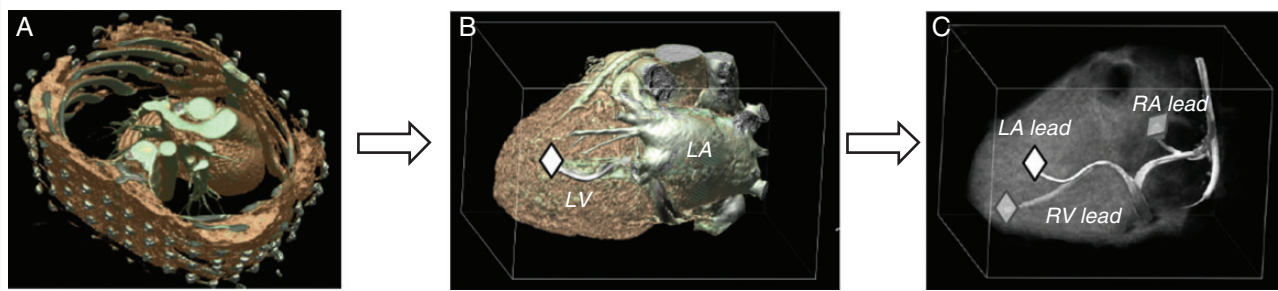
Computed tomography-based volume rendering, three-dimensional heart reconstruction, and marking of distal tip of the coronary sinus, right atrial, and right ventricular pacemaker lead. (A) Computed tomography of torso and heart, volume rendering. (B) Three-dimensional heart reconstruction, volume rendering after segmentation using the non-transparent mode (distal tip of coronary sinus lead is marked). (C) Three-dimensional heart reconstruction, volume rendering after segmentation using the semi-transparent myocardial mode. This mode allows simultaneous visualization of the epicardial coronary sinus lead and the endocardial right atrial and ventricular pacing leads.
